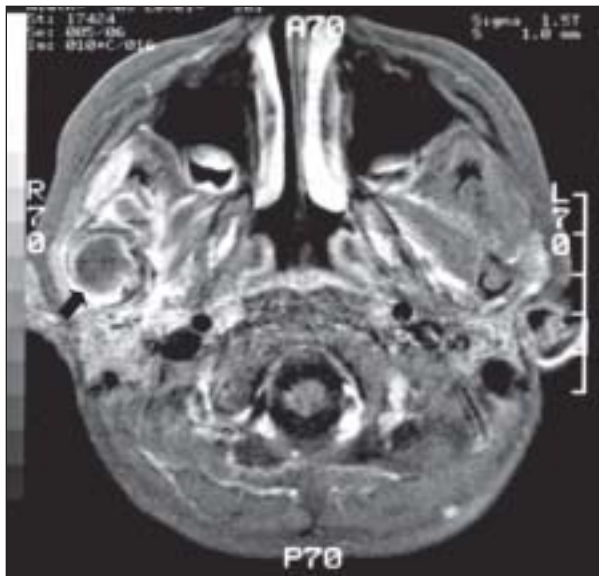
MRI scan showing osteolytic soft tissue mass on the right mandibular condyle and neck.
